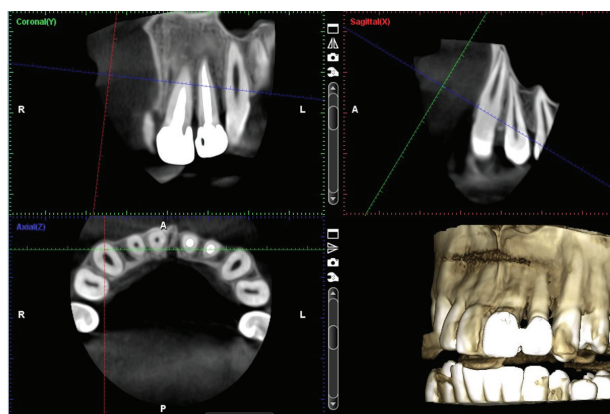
Showing six-month follow-up CBCT image.
